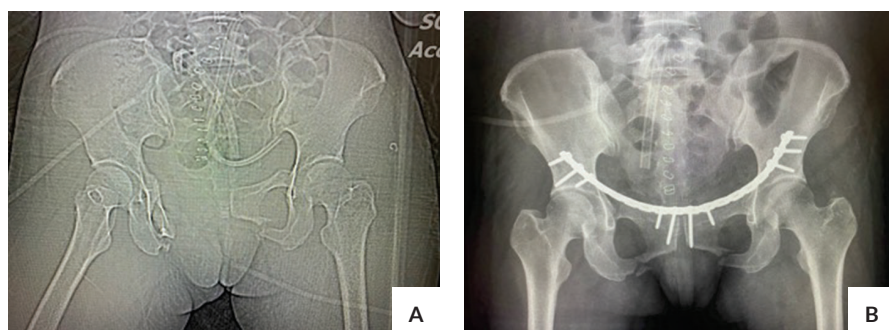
Radiographs from Patient 9 – Female, 35-year-old, car accident. (A) Pre-operative CT scan, (B) Immediate post-operative.
